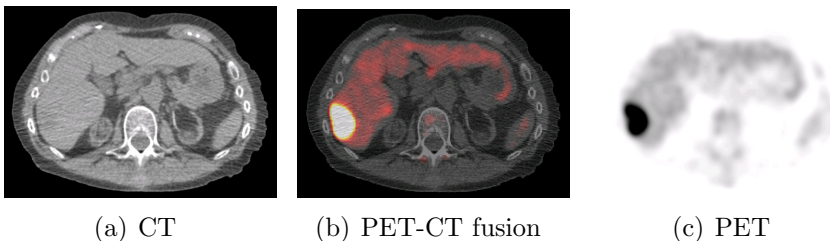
CT and PET images from a PET-CT combined device
